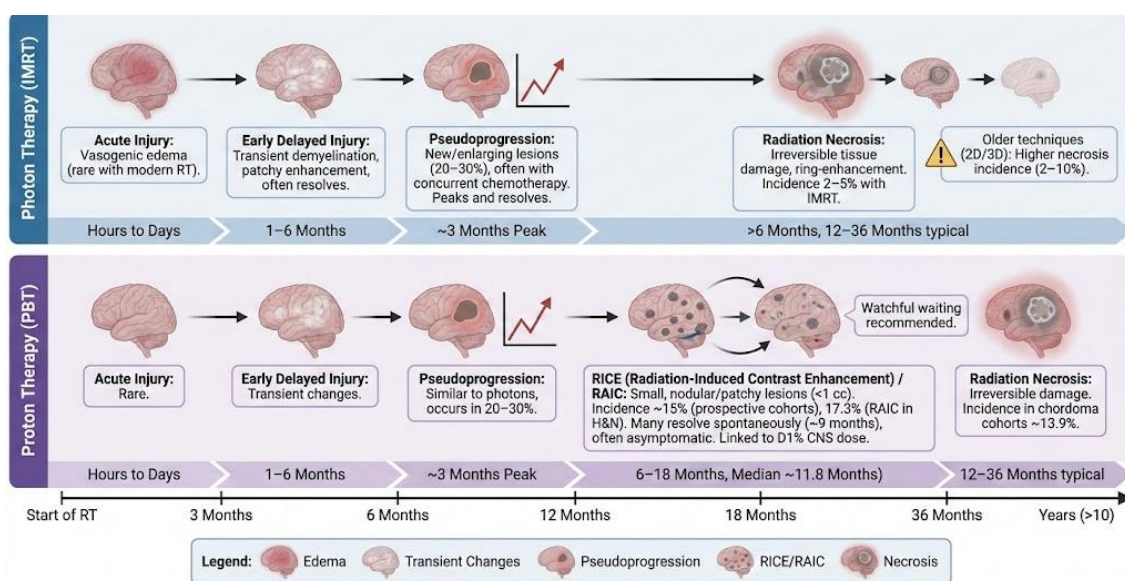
Temporal evolution and radiographic characteristics of radiation-induced brain injury (RIBI) following photon versus proton therapy.
